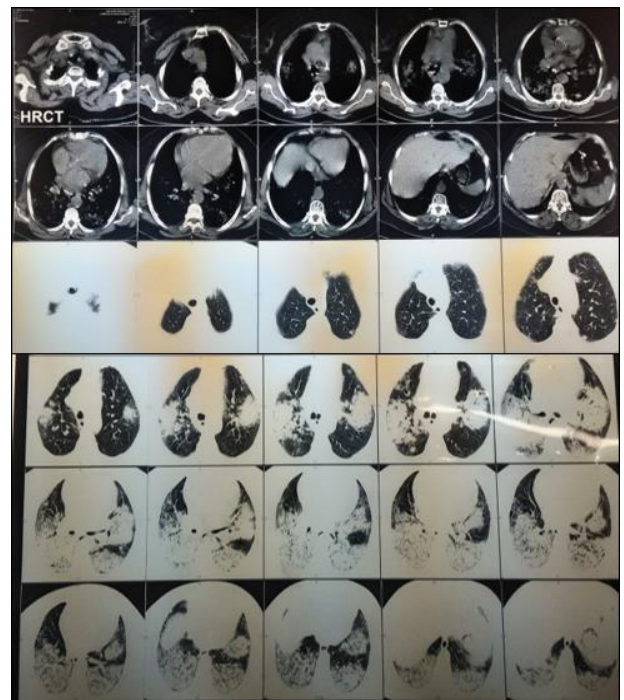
Radiological investigation - High resolution computed tomography (HRCT) - thorax.
